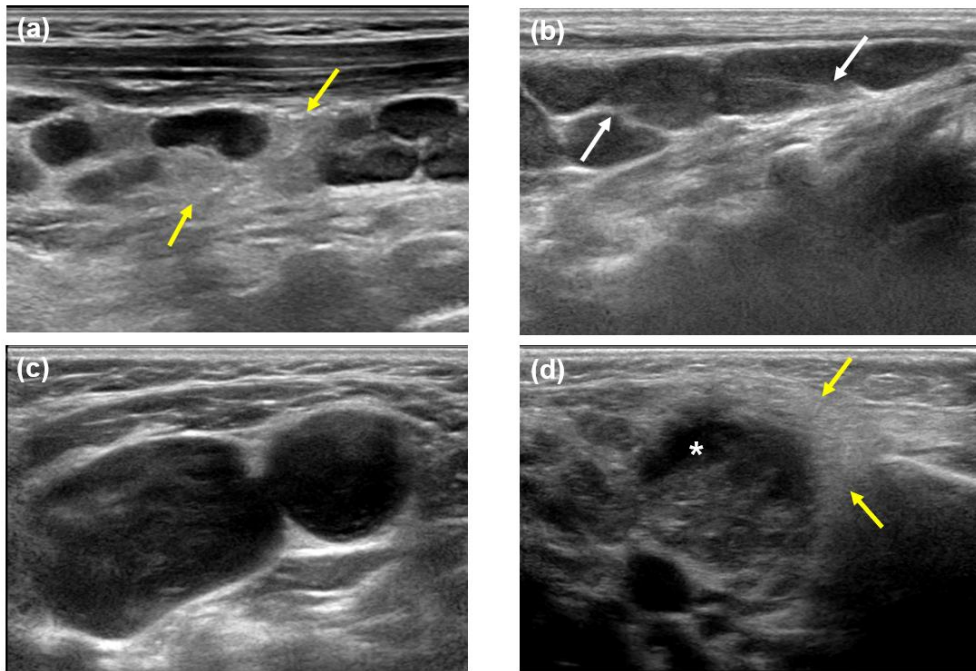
Representative ultrasonographic images in patients with Kikuchi's disease, reactive hyperplasia, lymphoma, and suppurative lymphadenitis
